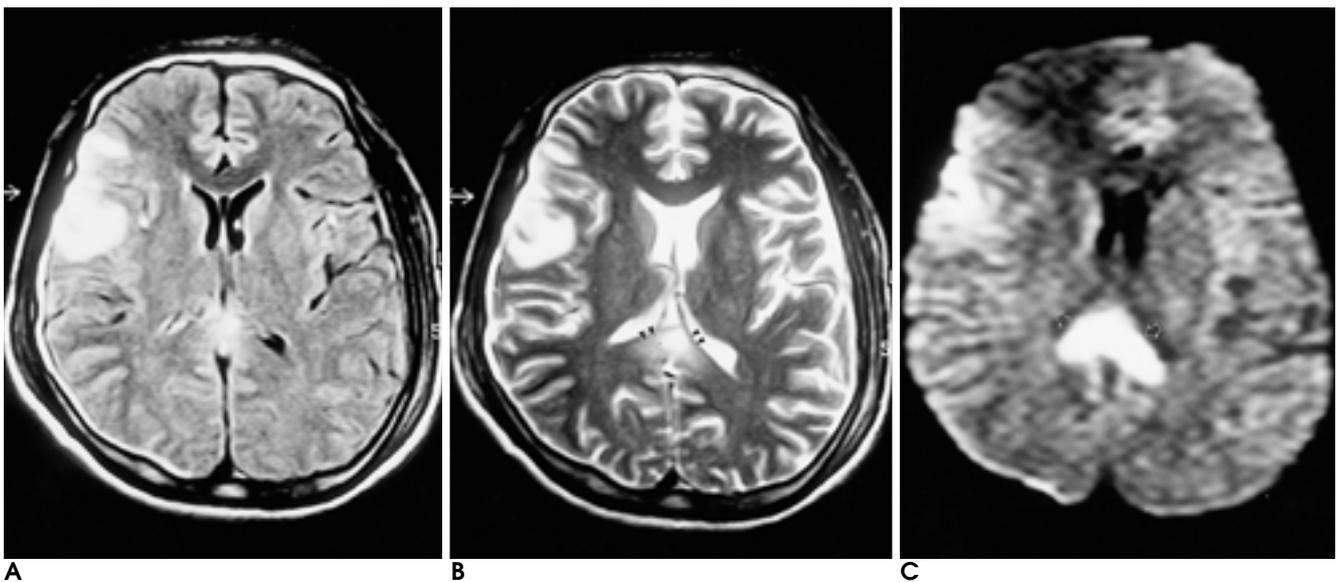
Diffuse axonal injury in 34-year-old man. FLAIR(A), T2 FFE(B) and diffusion weighted(C) images show the corpus callosum splenial high signal intensity due to diffuse axonal injury. Diffusion weighted images shows the corpus callosum high signal intensity more conspicuously than other pulse sequence images Right. temporal lesion detected more conspicuously on FLAIR (A) than other pulse sequence images.
